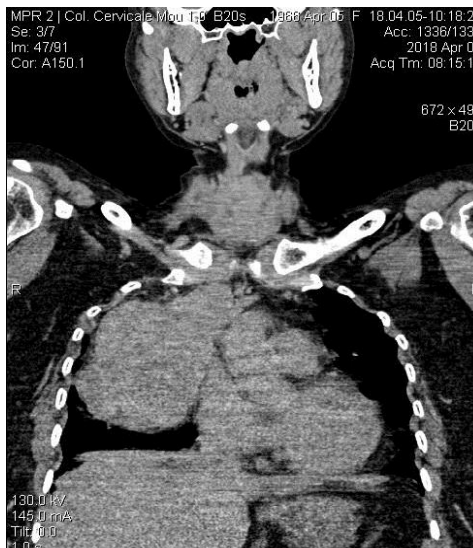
CT appearance (front view) showing a giant endothoracic mass deviated in the right lung field
